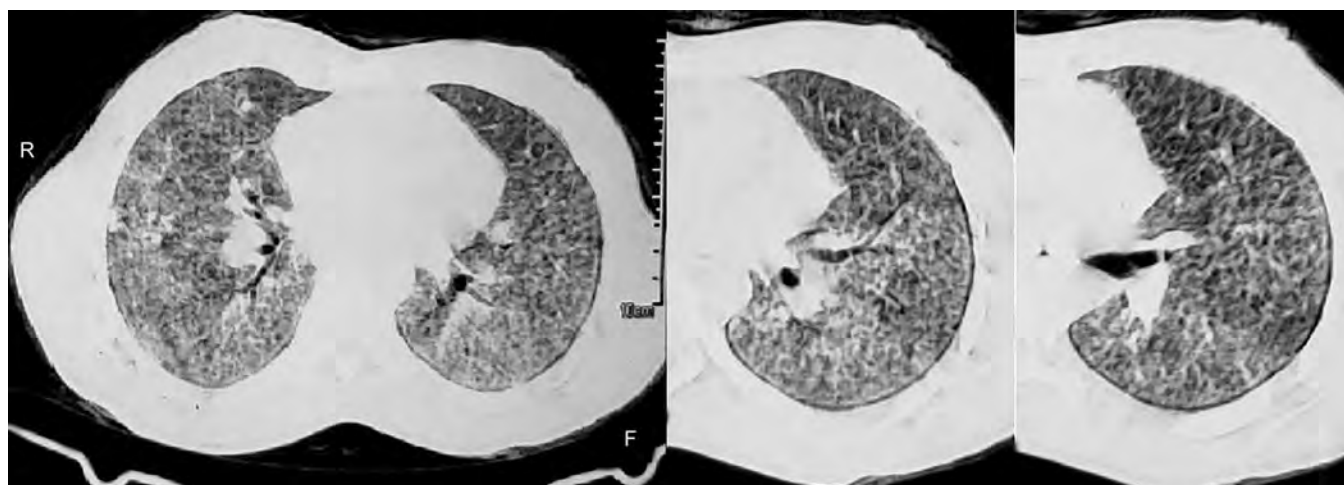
CT scan chest showing peripheral subpleural linear sparing of lesions producing "black pleura sign"
